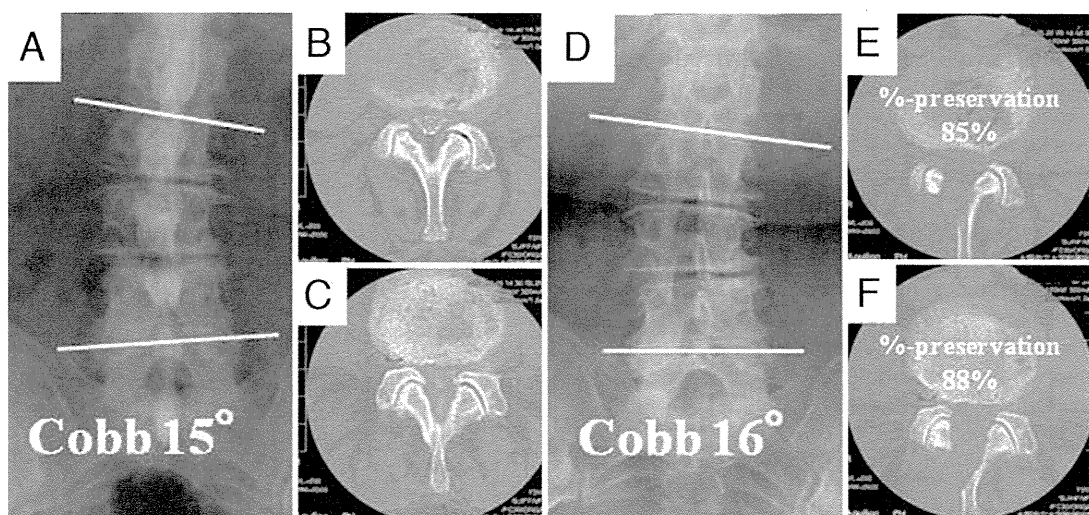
Imaging studies obtained in a 74-year-old woman who underwent MBDU from the convex side. Preoperative standing AP radiograph (A) and preoperative axial CT scans of the L3–4 level (B) and L4–5 level (C). The spinous processes are inclined to the contralateral side, providing a wider view from the convex than the concave side. Postoperative AP radiograph (D) after 5 years demonstrating no obvious postoperative spinal instability. Postoperative axial CT images at L3–4 (E) and L4–5 (F) revealing good preservation of the facet joints (percentage of facet preservation [%-preservation] on the approach side: L3–4, 85%; L4–5, 88%).
